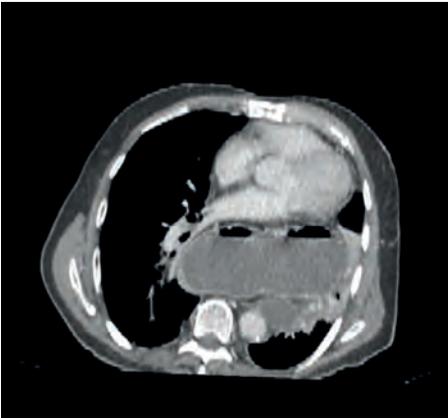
Transverse CT scan of the thorax- , demonstrating a giant hiatus hernia and organoaxial gastric volvulus.
